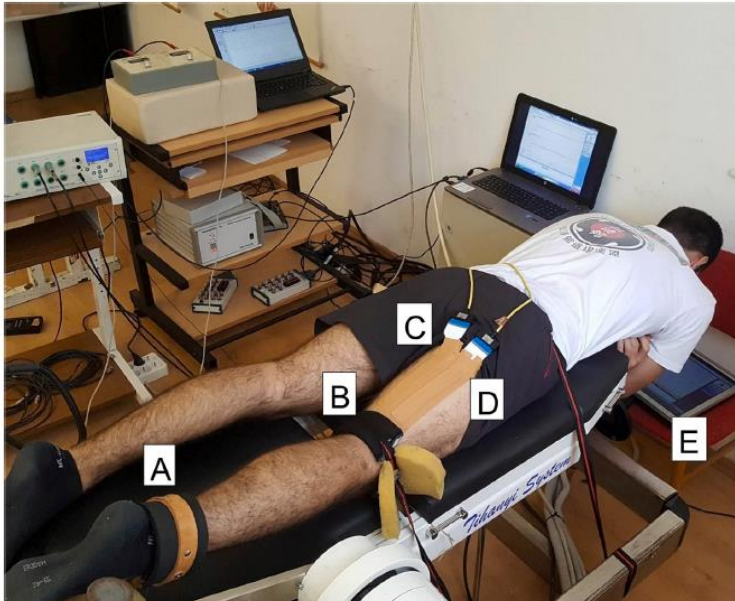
PARTICIPANTS LAY PRONE ON THE TESTING BENCH WITH THE RIGHT KNEE FLEXED TO 30°. LINEAR EMG ARRAYS WERE PLACED OVER THE RIGHT BICEPS FEMORIS LONG HEAD (D) AND SEMITENDINOSUS (C) AFTER DEFINING MUSCLE BORDERS WITH ULTRASONOGRAPHY. KNEE FLEXION AND HIP EXTENSION FORCES WERE MEASURED WITH FORCE TRANSDUCERS ATTACHED PROXIMAL TO THE MALLEOLI (A) AND PROXIMAL THE POPLITEAL FOSSA (B), RESPECTIVELY. VISUAL FORCE-TIME CURVE FEEDBACK WAS PROVIDED ON A SCREEN PLACED IN FRONT OF THE PARTICIPANT (E).
